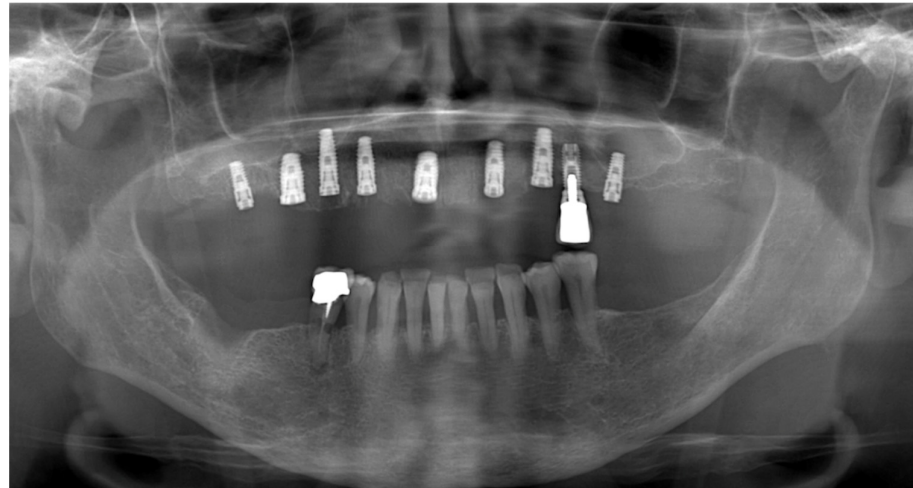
The panoramic radiograph obtained 3 months after implant placement revealed no evidence of osteonecrosis.
